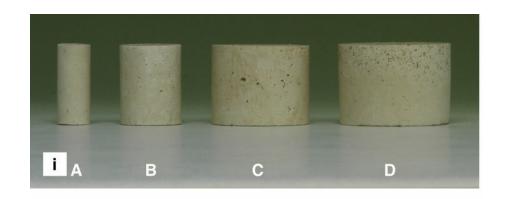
(i) Front view of five apparently similar cylinders made from plaster of Paris. (ii) A plan view shows the objects are in fact different shapes. (iii) Radiographs show how objects of different shape, but made of the same material, produce different radiographic images.
